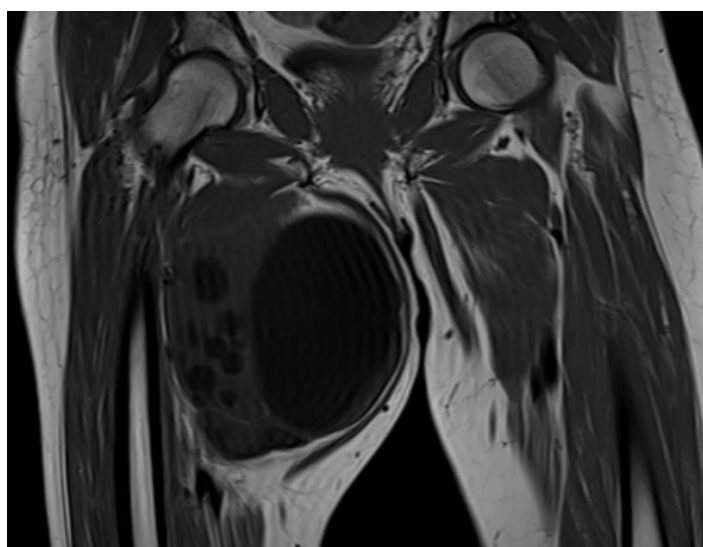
MRI. Coronal T1-weighted image: well-defined, multivesicular lesion located in the medial compartment of the thigh. Vesicles with distinctly hypointense signal compared to the rest of the cystic fluid
